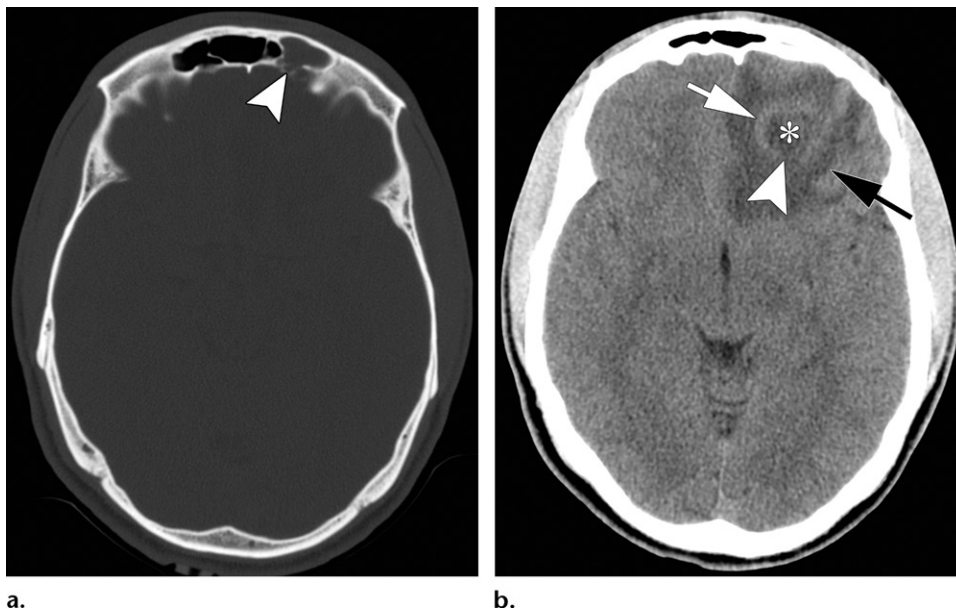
Left frontal sinusitis and left frontal lobe abscess in a 22-year-old man. (a) Axial nonenhanced CT image (bone window) shows an opacified left frontal sinus, with thinning of the posterior wall of the sinus (arrowhead). (b) Axial nonenhanced CT image obtained just superior to a shows an abscess with a low-attenuation center (*), a thicker abscess rim (white arrow), and surrounding edema (black arrow). Typical thinning of the abscess capsule (arrowhead) is present on the side facing the ventricle. These findings were confirmed at contrast-enhanced MRI (not shown). Culture analysis revealed α -hemolytic *Streptococcus* as the causative organism.
